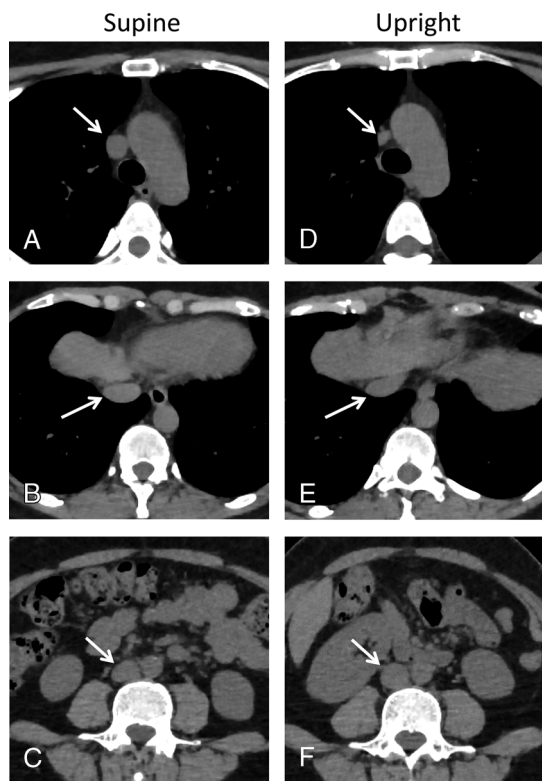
Difference of area and flattening of the vena cava at 3 levels. At the superior vena cava, directly below the junction of the bilateral cephalic vein, the area was 143 mm² in supine CT (A) and 51 mm² in upright CT (D) (64% smaller). The flattening was 0.12 in supine CT (A) and 0.38 in upright CT (D) (3.2-fold increase). At the vena cava, at the level of the diaphragm, the area was 286 mm² in supine CT (B) and 259 mm² in upright CT (E). The flattening was 0.51 in supine CT (B) and 0.58 in upright CT (E). At the inferior vena cava, directly above the iliac bifurcation, the area was 199 mm² in supine CT (C) and 241 mm² in upright CT (F) (21% larger). The flattening was 0.3 in supine CT (C) and 0.1 in upright CT (F) (66% decrease).
